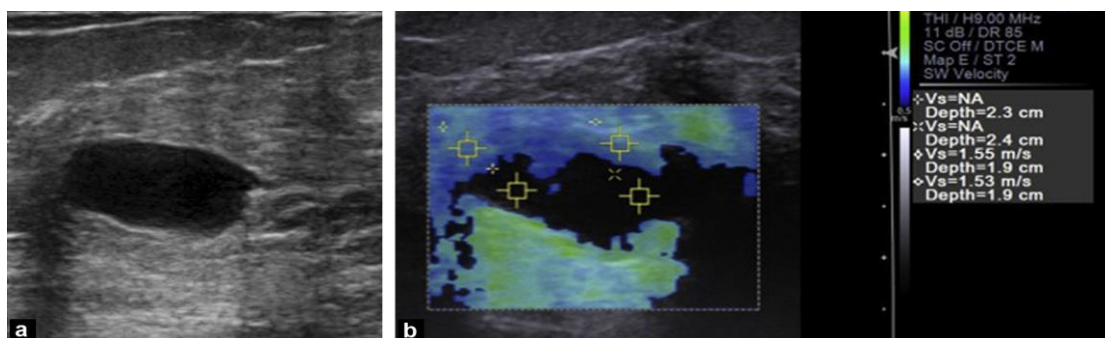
Cyst. Acoustic Radiation Force Impulse mode . The shear waves are not generated when the ultrasound beam encounters a pure cyst (a) as in this example. With this technique, the defect appears as an area of blank
